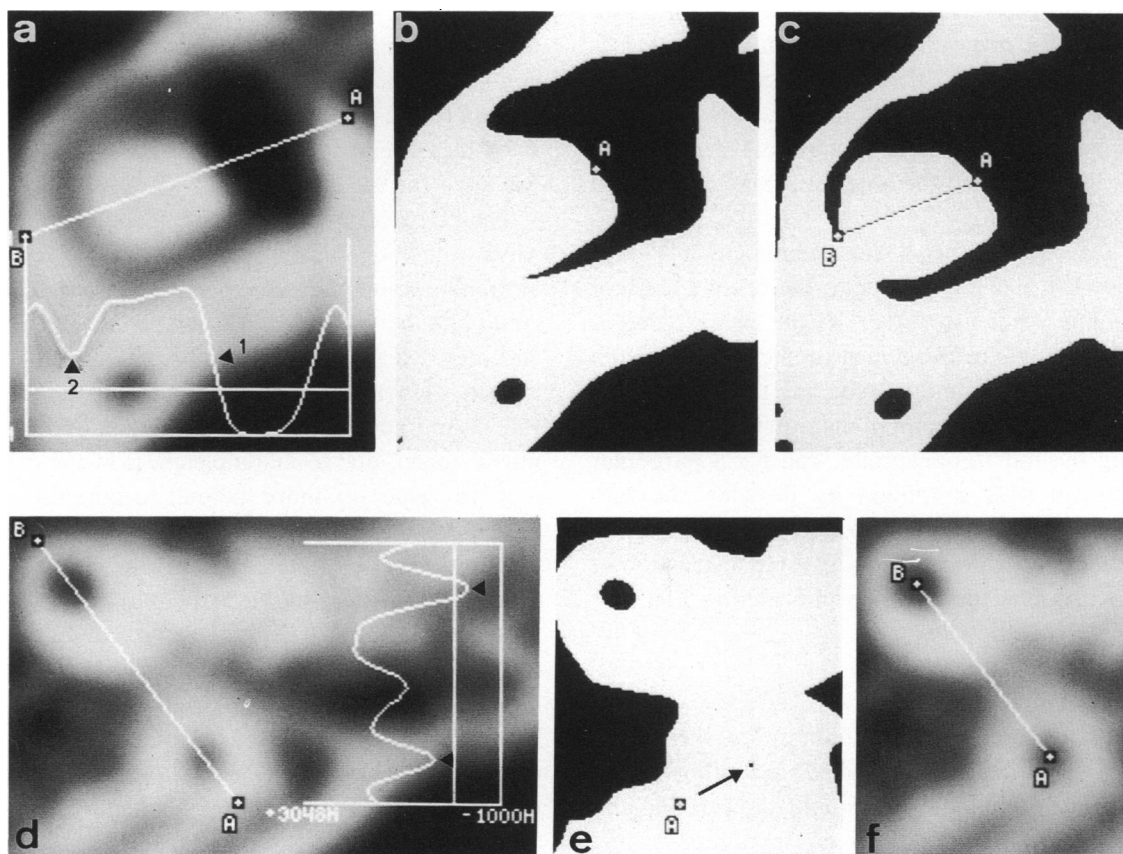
Method of taking the labyrinthine measurements from CT scans. See text for a detailed description of the procedures.
